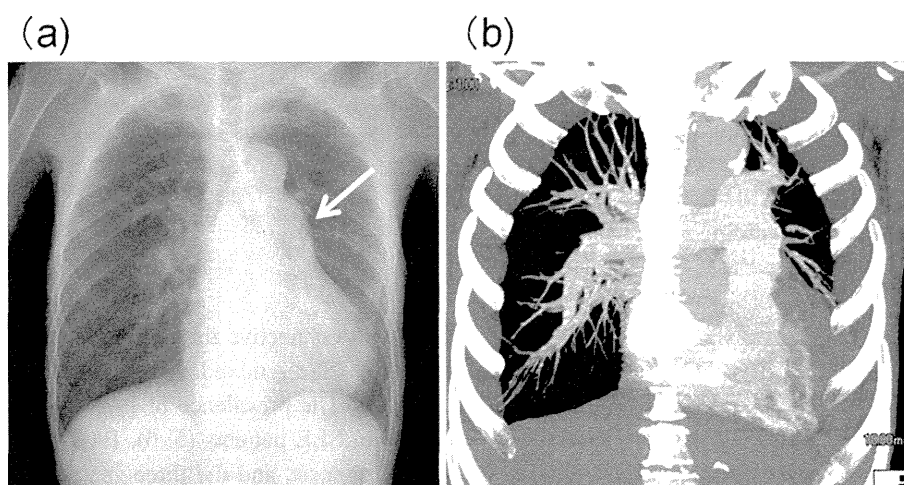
The chest X-ray and CT findings upon admission. (a) The chest X-ray showed a protrusion of the left second arch (arrow). (b) Enhanced CT showed no signs of pulmonary embolism.
